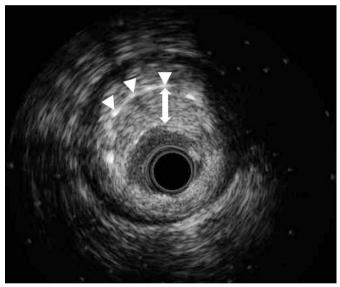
In intravascular ultrasound on right coronary artery after stent deployment, there was total occlusion by extensive thrombus and there was no evidence of edge dissection, incomplete stent apposition or underexpansion (arrow heads showed stent struts and arrow showed thrombus).
